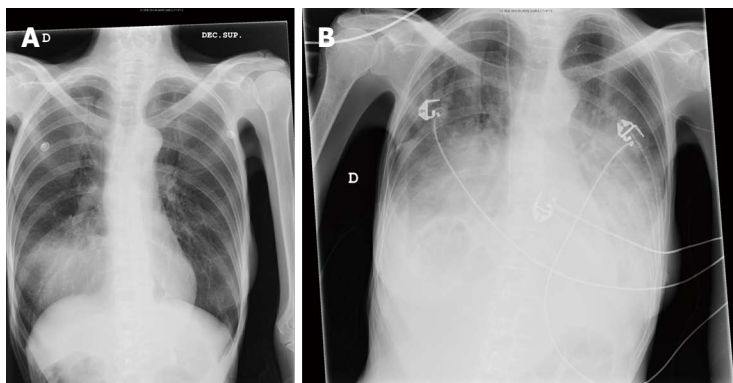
Chest X-ray on admission (A) and after the episode of atrial tachycardia (B) showing signs of severe heart failure.
